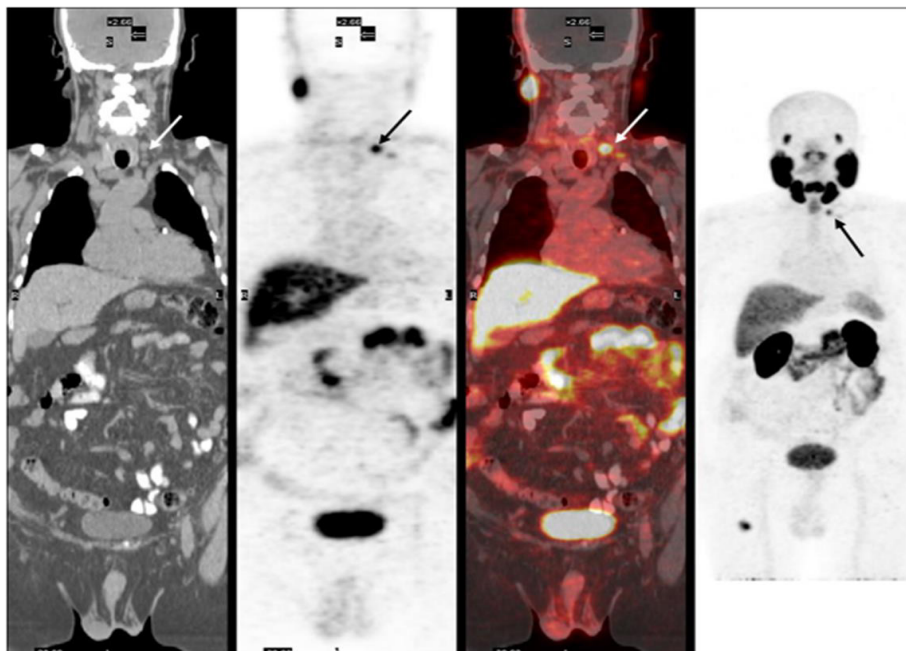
Pathological involvement of the left supraclavicular region lymph node on ^{68}Ga PSMA PET CT images in the patient with PSA recurrence. The patient who received RT and hormonal therapy had an increase in PSA level 2 years after the treatment (trigger PSA: 5.8 ng/ml, PSAdt: 2 months, PSAv: 12 ng/ml/year).
